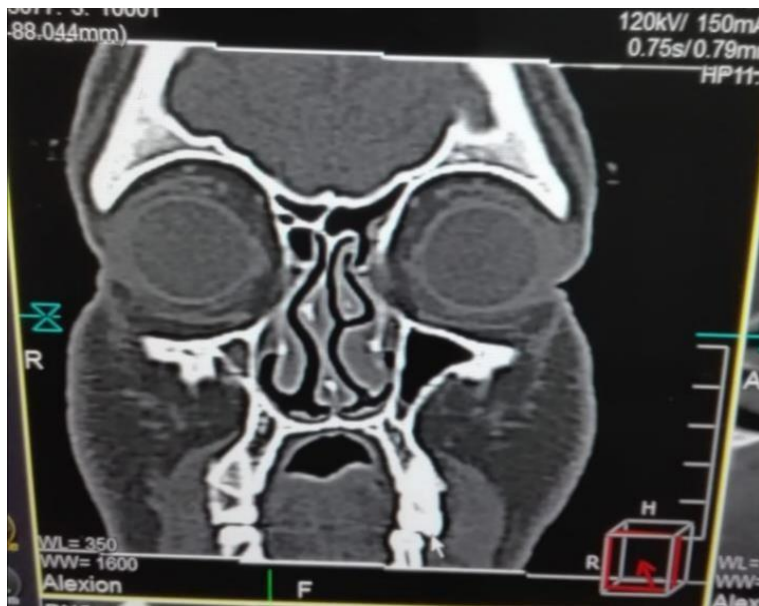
shows 40 years old male coronal CT image with acute sinusitis in lt ethmoid
